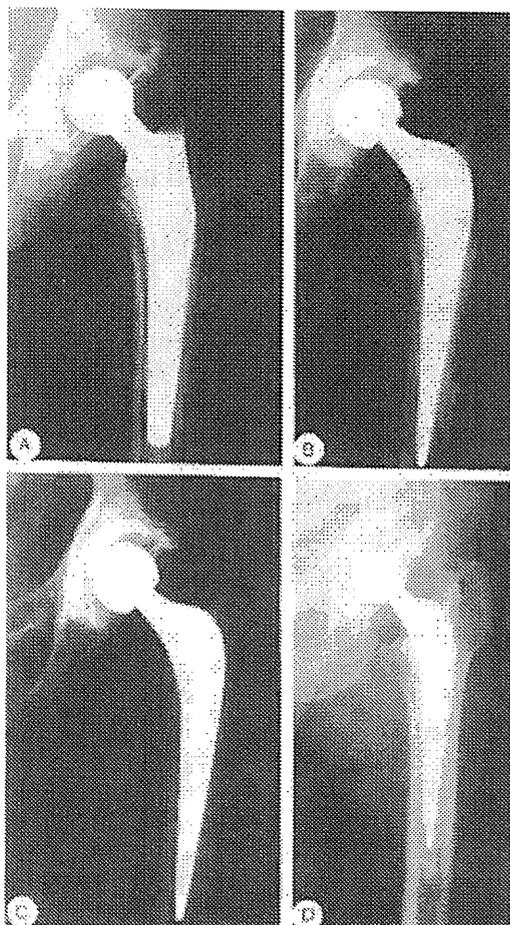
Revision of an acetabular and femoral loosening of a straight-stem Muller prosthesis. (A) The preoperative situation. Moderate migration of the cup with radiolucent lines in all 3 segments. Around the stem a clear radiolucent lining is visible around the cement mantle. (B) Radiograph done immediately after the revision with the impacted morsellized chips in the acetabulum and femur. The X-Change Revision System and the Exeter Hip System were used. (C) Radiograph 1 year after surgery. Neither migration nor radiolucency is visible. (D) Radiograph 2 years after surgery. The position of the cup is the same as it was immediately after surgery. No migration has occurred. Signs of remodeling of the impacted graft are visible at the femoral side.
